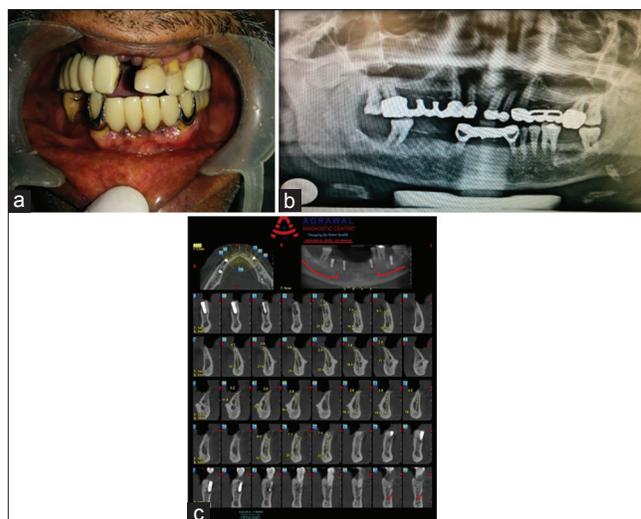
(a) Clinical view at the initial visit, (b) The radiograph showed generalized alveolar bone loss and apically involved teeth, (c) Cross-sectional view of computed tomogram before extraction
